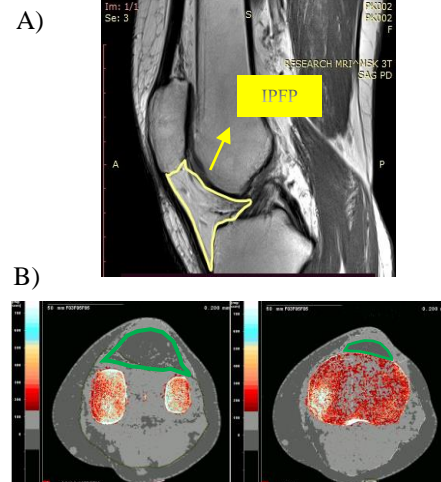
Segmentations from MRI outlined in yellow (A) and pQCT outlined in green (B) isolating the IPFP.
